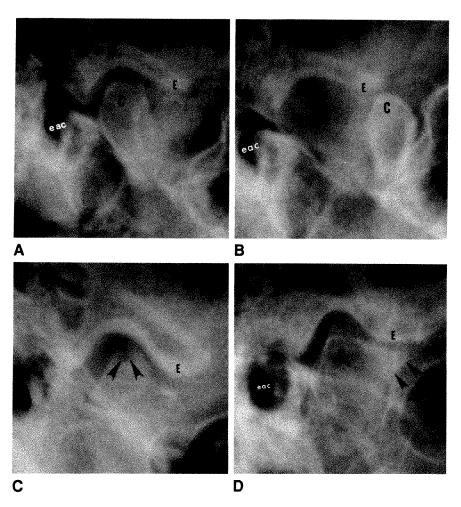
A and B, Plain films show normal temporomandibular joint in closed-mouth (A) and open-mouth (B) positions. Note central location of condyle (C) within glenoid fossa with mouth closed (A). Apex of condyle passes to, or slightly beyond, eminence (E) with mouth fully opened (B). eac = external auditory canal.
